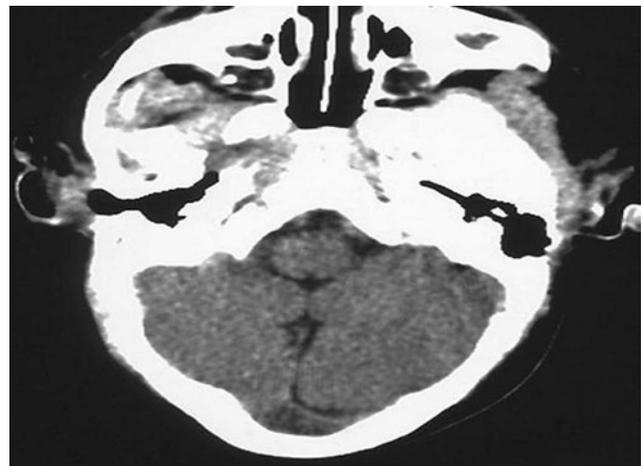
Axial computed tomographic scan of the head through the posterior fossa of a child with vitamin D–deficient rickets and Chiari 1 malformation. Note the small posterior fossa volume due to bony overgrowth.
